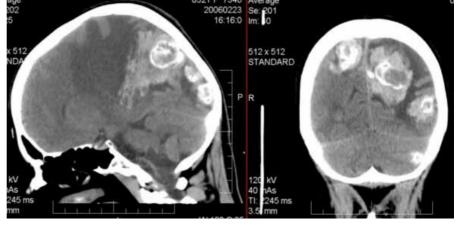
Brain CT showing multiple cerebral lesions and oedema
